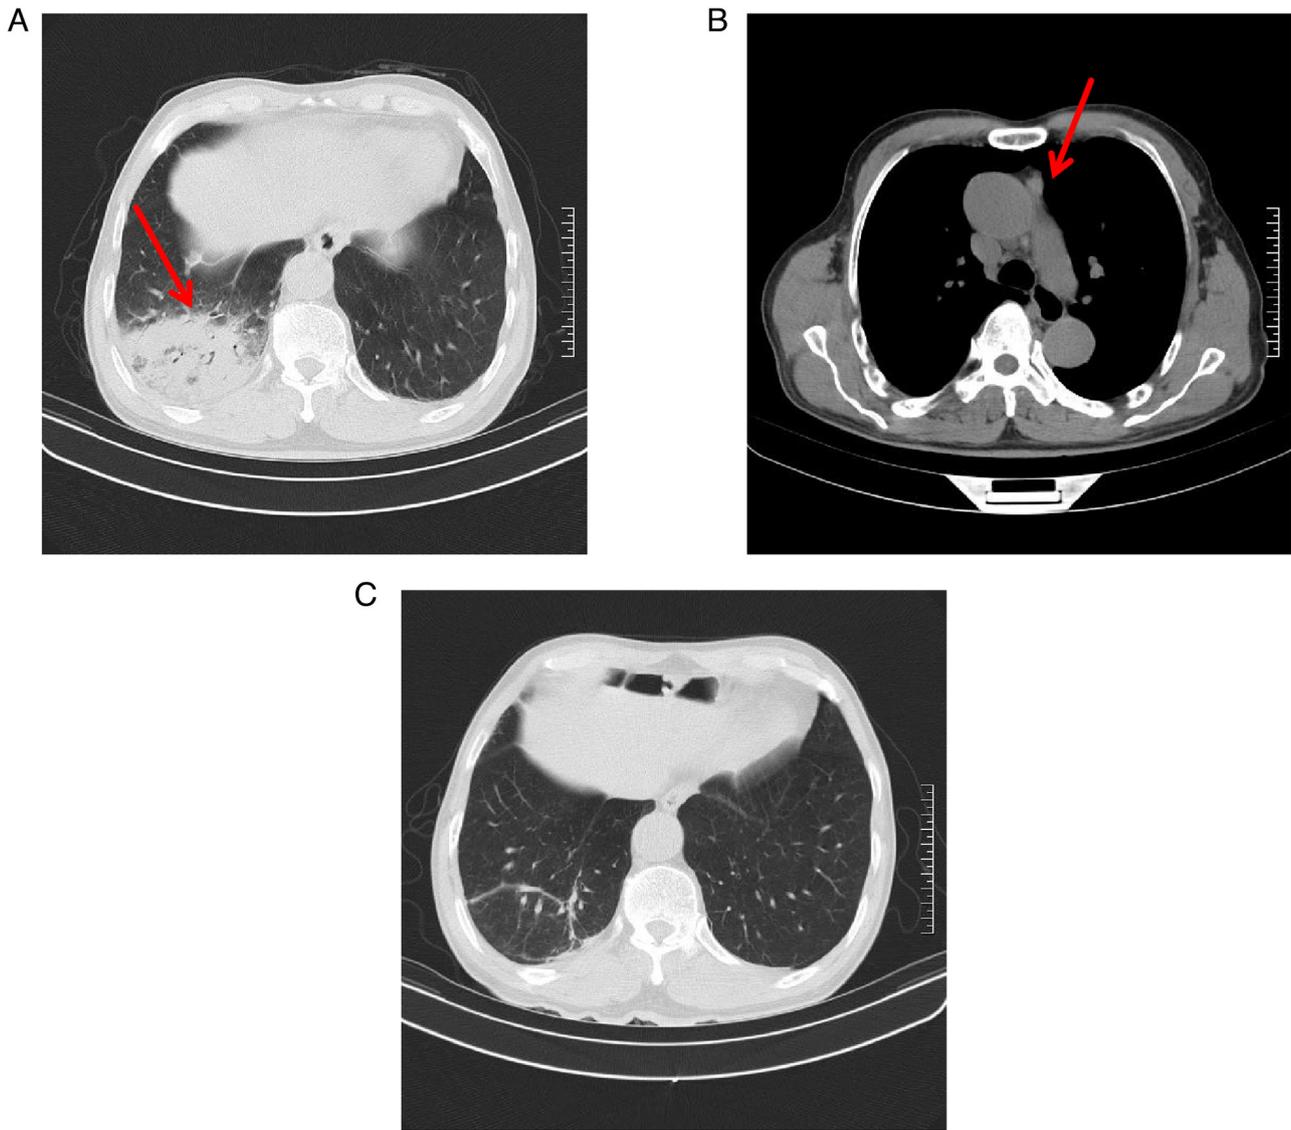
Results of chest CT examination in April 2021. (A) A patchy hyperdense shadow in the lower part of the right lung with partial consolidation, as well as (B) a soft tissue nodule in the anterior mediastinum with a size of  $\sim 1.8 \times 2.0$  cm (indicated by red arrow). (C) Re-examination of chest CT in May 2022 showed a patchy hyperdense shadow in the lower lobe of the right lung with partial consolidation, which was evidently absorbed compared with the CT scan carried out in April 2021. CT, computed tomography.
